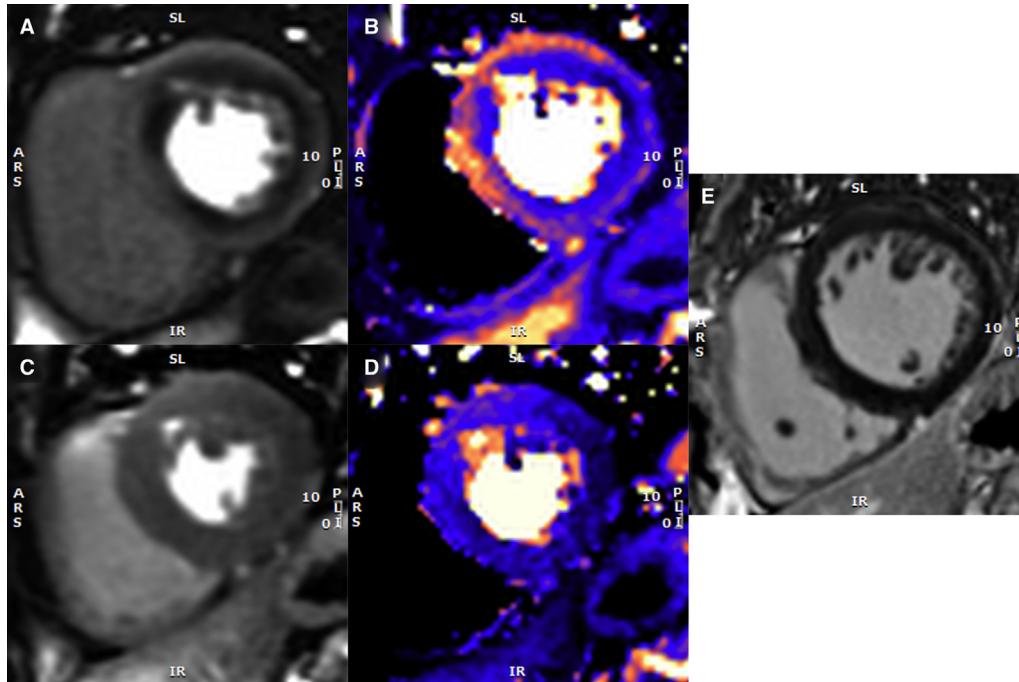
Cardiovascular magnetic resonance imaging in chronic coronary syndrome. Patient presenting with stable exertional angina. (A) Adenosine stress perfusion imaging demonstrates subendocardial perfusion defects in all three coronary territories. A still image at peak contrast uptake in the mid-ventricular slice is shown. (B) Quantitative perfusion map shows reduced myocardial blood flow (blue color) in the subendocardial anterior and antero-septal segments and transmurally in the inferior and lateral wall. (C) Corresponding myocardial perfusion imaging at rest shows homogenous contrast distribution. (D) Myocardial perfusion map shows homogenous myocardial blood flow in all segments. (E) Late gadolinium enhanced images show no evidence of myocardial infarction and all coronary territories are viable. Cine images (not shown) showed normal contraction in all segments. Invasive coronary angiography showed severe three vessel coronary artery disease.
